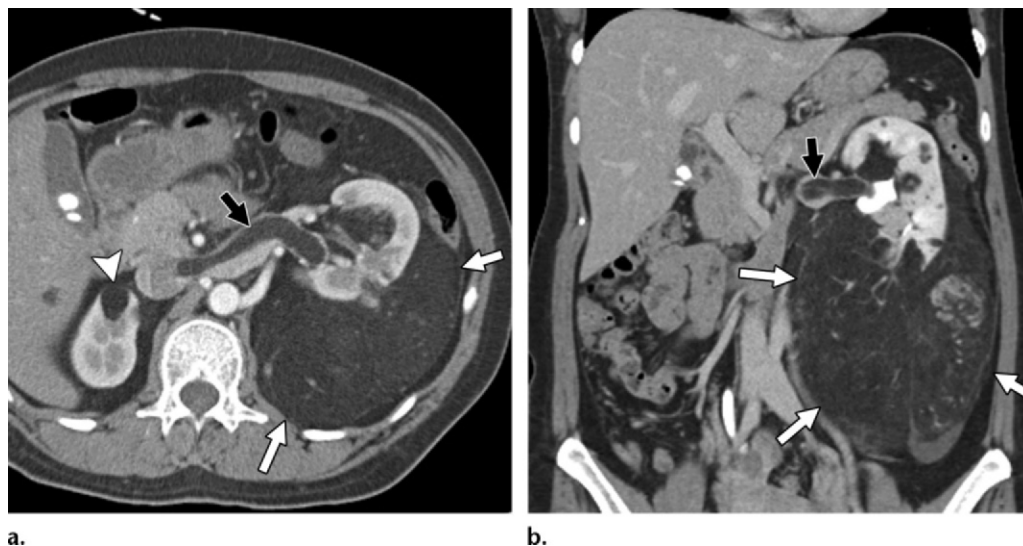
Renal AML in a 48-year-old woman with a history of tuberous sclerosis. Axial (a) and coronal (b) contrast-enhanced CT images show a left renal fat-containing mass (white arrows). Note the fatty tumor thrombus in the left renal vein (black arrow). A fat-containing lesion is also seen in the right kidney (arrowhead in a).
